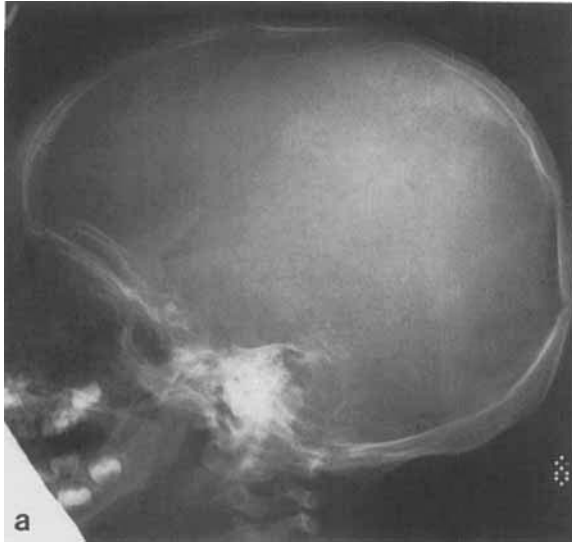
a: Propositus (patient 1), age 3 years. Radiograph demonstrates small occipital exostoses and Wormian bones posteriorly. b: Propositus (patient 1), age 15 years. Radiograph demonstrates enlargement of occipital exostoses and anterior wedging of cervical vertebrae.
